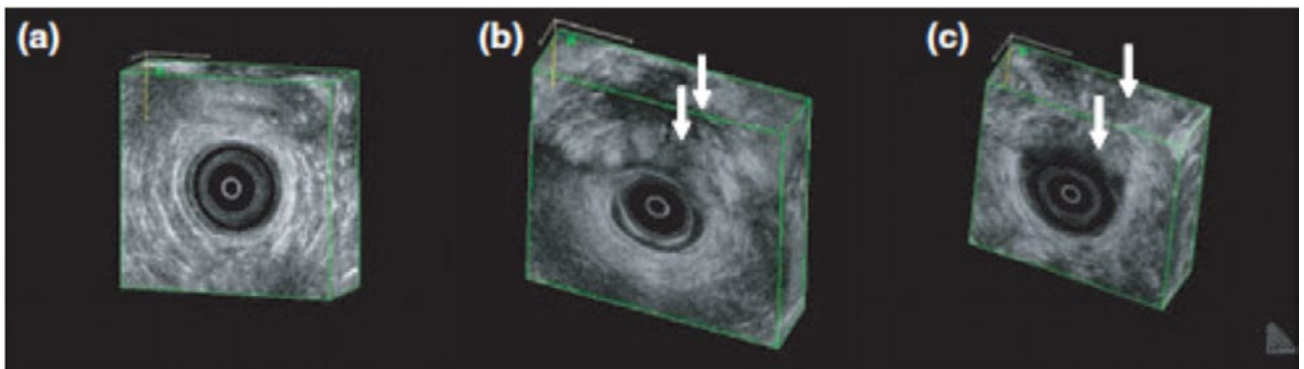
Three-dimensional endoanal ultrasound showing no (a), partial (b) or complete EAS defect (c). Arrows indicate an EAS defect in the sagittal view (11).
